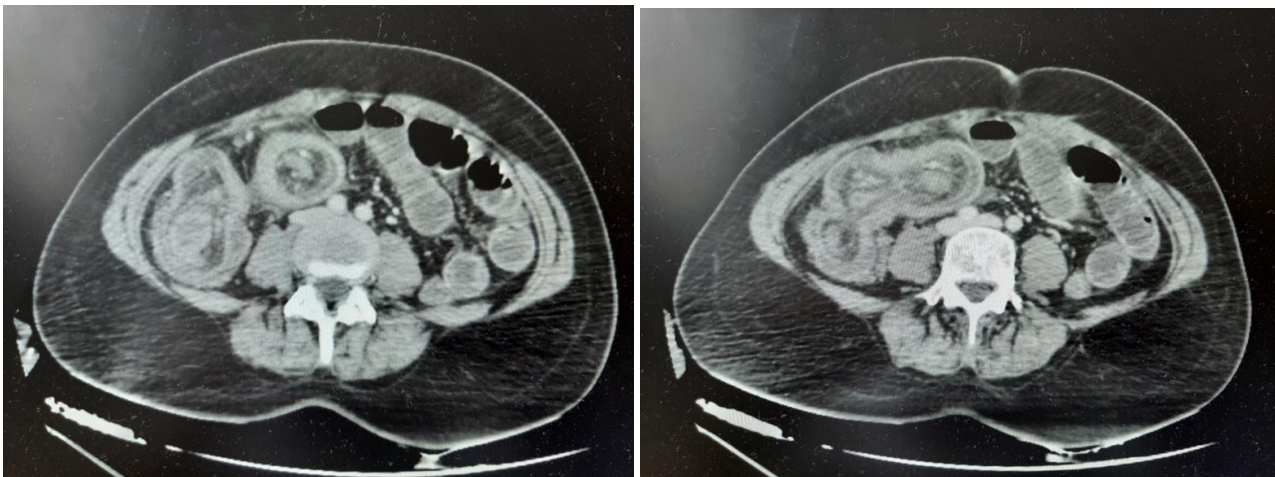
Abdominal CT scan showing the ileocolic intussusception.
